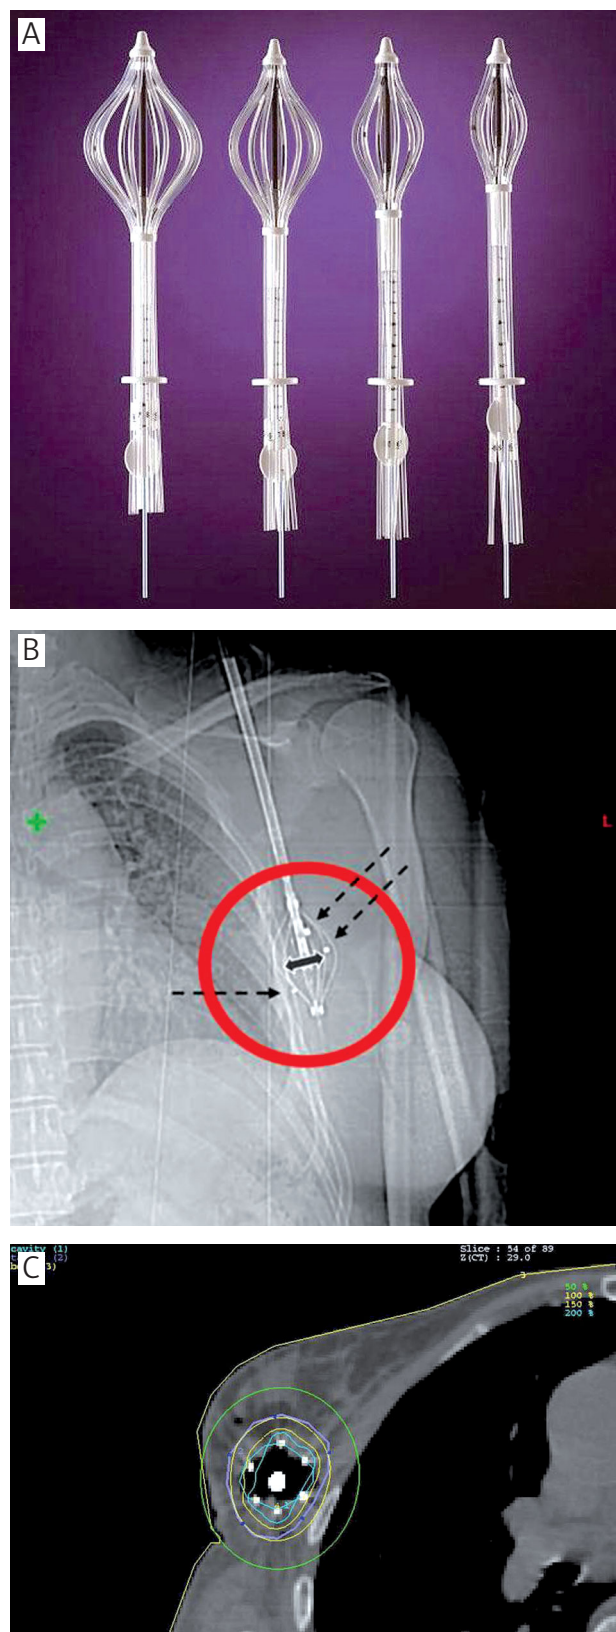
A) Contura balloon applicator (SenoRx®) [30]. B) Contura balloon applicator on CT section with the distribution of isodoses, 5 channels for iridium visible
